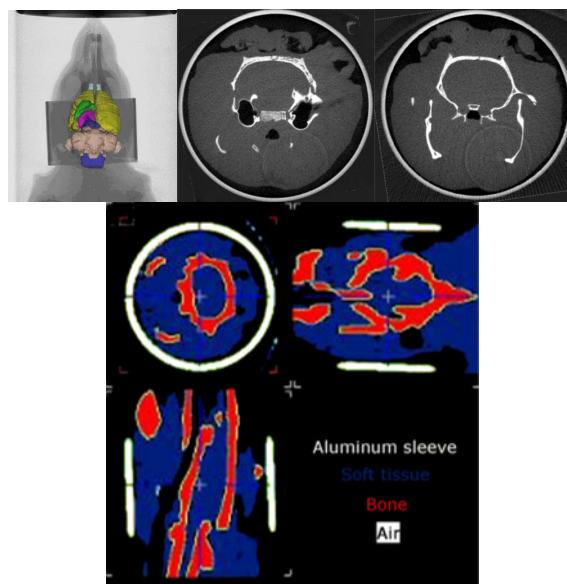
Generation of CT-based attenuation map
